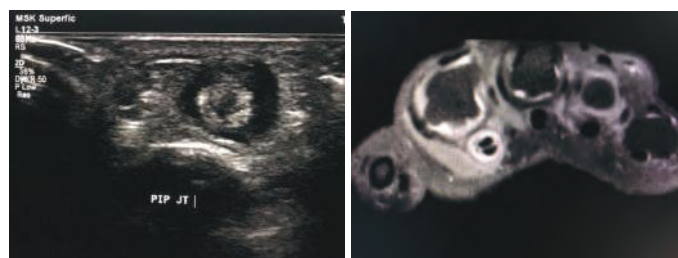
Comparison between the ultrasound and MRI images demonstrating fluid around the flexor tendon sheath with tenosynovitis.
